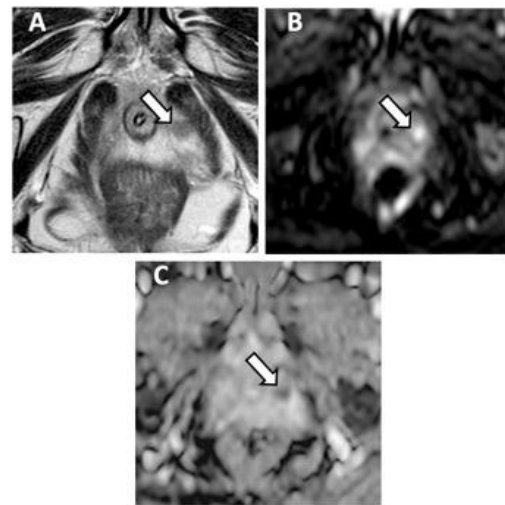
74-year-old patient with iXip 0.750. Axial T2-weighted image (A) shows a homogeneous hypointense area in the left peripheral zone at the apex of the prostate with high signal on DWI at high b-value (B) and low ADC (C). This area was categorized as PI-RADS 4. A Gleason 7 (4 + 3) adenocarcinoma was found on fusion biopsy.
